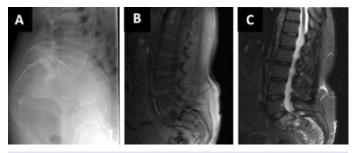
(a) Lateral radiograph of the lumbosacral spine showing Grade IV L5/S1 spondylolisthesis. (b) T1 sagittal magnetic resonance imaging (MRI) of the lumbar spinal stenosis (LSS) showing the L5/S1 Grade IV spondylolisthesis(c) T2 short tau inversion recoverysagittal MRI of the LSS showing Grade IV L5/S1 spondylolisthesis and severe spinal canal stenosis.
